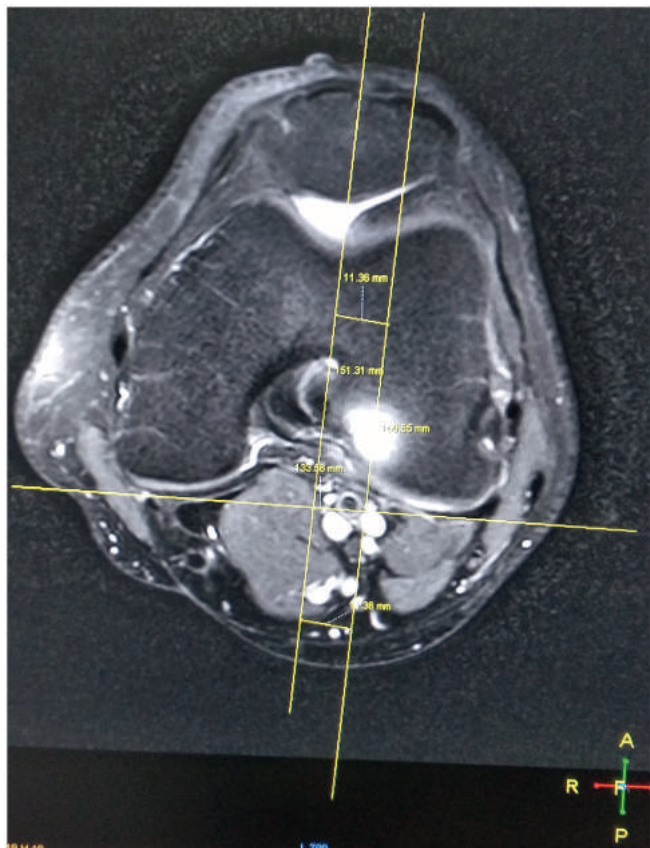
Image depicting the method of calculation of TT-TG distance on MRI.
